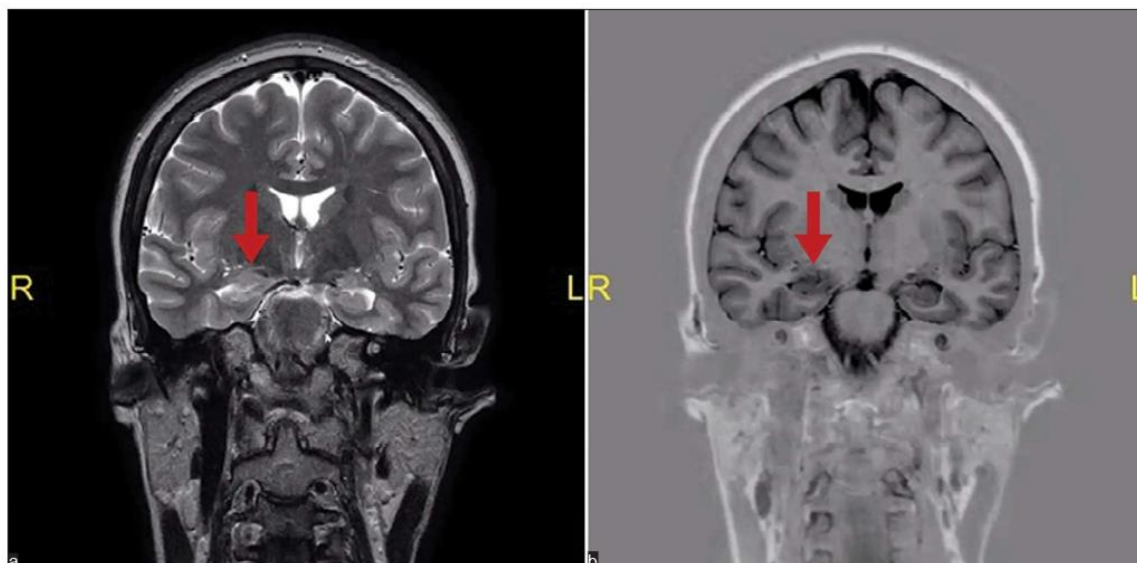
Coronal T2-weighted, and T1-weighted inversion recovery magnetic resonance imaging brain scan (Panel a and b respectively) of a study participant showing evidence of right-sided hippocampal atrophy (indicated by arrows).
